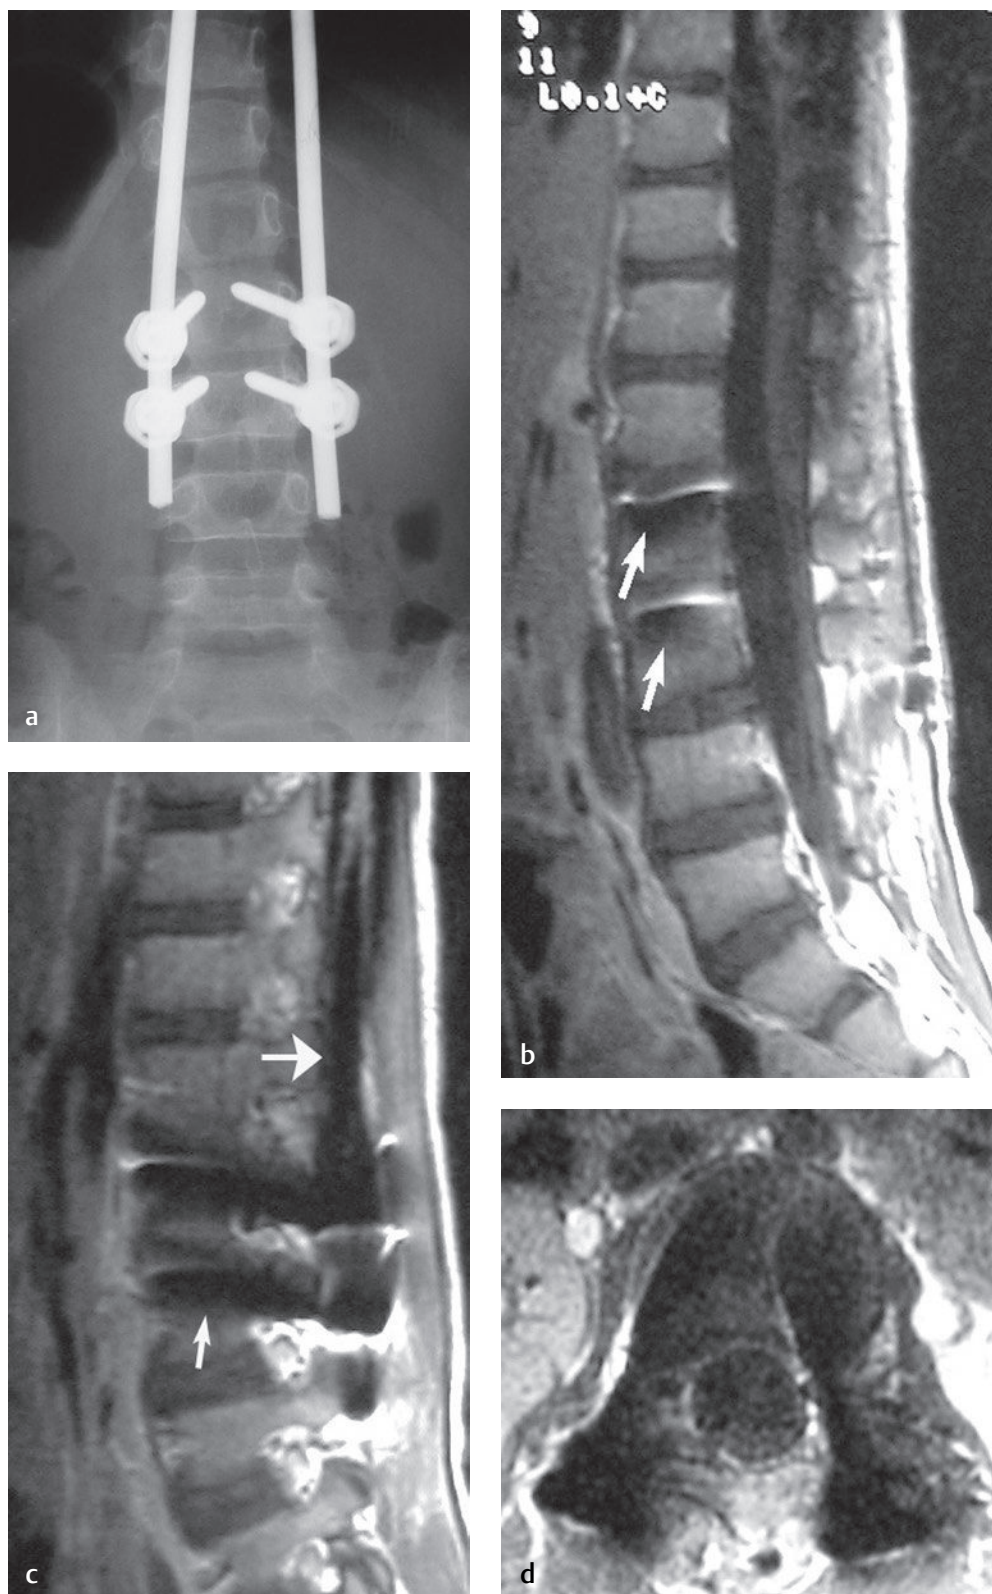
A 6-year-old boy with a history of high-grade astrocytoma underwent resection, multilevel laminectomy, and posterior spinal arthrodesis from T4-L3 with titanium pedicle screws, hooks, and rods. (a) An AP radiograph 6 weeks after surgery. (b) A midline sagittal post-gadolinium T1-weighted image enables visualization of the canal contents with only minimal artifact from the pedicle screws (arrows). (c) A parasagittal postgadolinium T1-weighted image shows a rod (arrow with a large head) and a pedicle screw (arrow with a small head), neither of which substantially degrades the image. (d) An axial postgadolinium T1-weighted image also shows the pedicle screws and a patent spinal canal.
